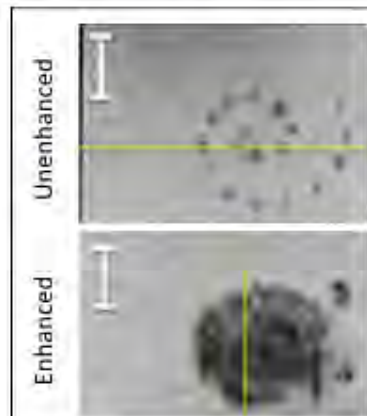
T2-weighted MR images of ultrasound thermal lesions in a uniform gel, placed in a spiral without (top) and with (bottom) controlled gas bubble generation from IV administered perfluorocarbon microdroplets. The latter greatly enhances heating only in the focal zone. Note the small, sparse lesions in the top, "unenhanced" image and the uniform coverage from larger lesions in the "enhanced" image. Both were obtained in the same exposure time and ultrasound output levels.
